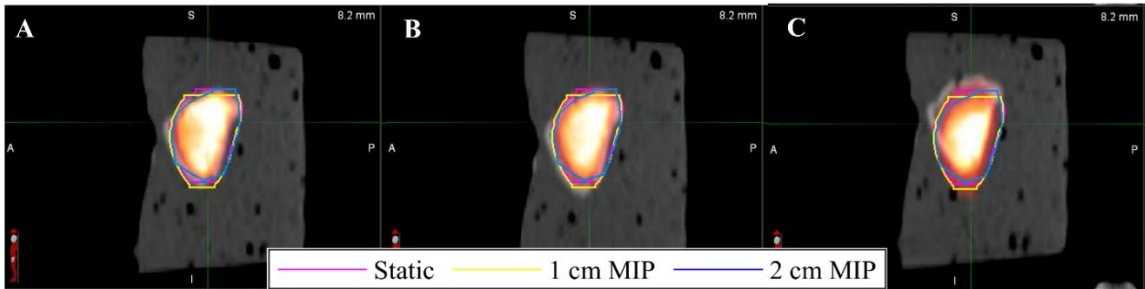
Segmentations generated using PET EDGE on A) Static, B) 1 cm dynamic, and C) 2 cm dynamic PET/CT scans.
